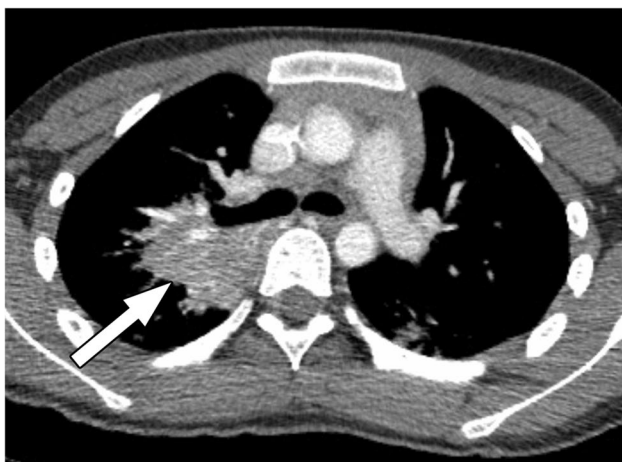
12-year-old boy with acute fungal infection due to blastomycosis. Axial chest CT image with IV contrast material shows right upper lobe consolidation (arrow). Although the morphology of the consolidation is mass-like, the fact that enhancing pulmonary vessels course through the area rather than being displaced by the area suggests consolidated lung parenchyma surrounding bronchovascular bundles rather than a true mass
